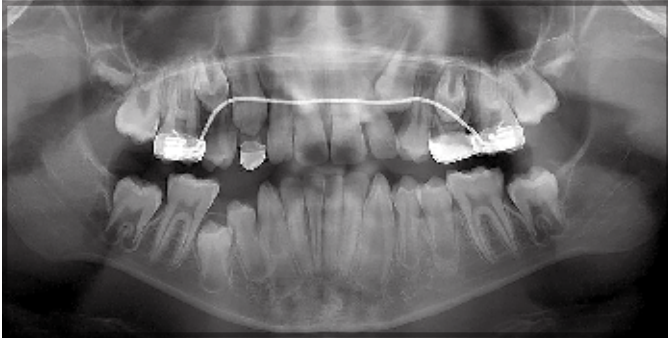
Case 1. Panoramic radiograph of a 10-year-old patient presenting for extraction of teeth 5, 12, 21, and 28, as well as tooth C, as requested by his orthodontist.
